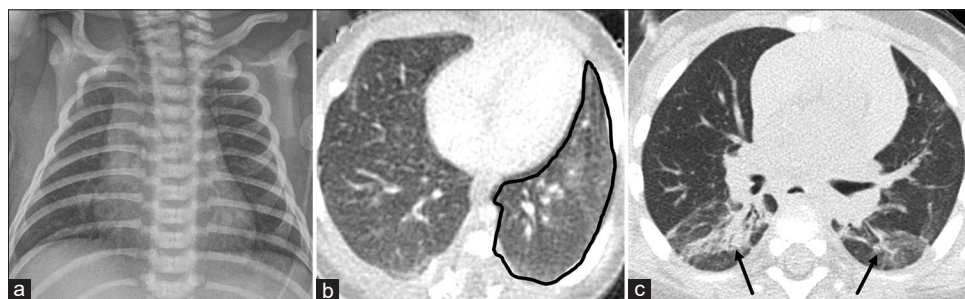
(a) Chest radiograph on day of life #2 in a term infant experiencing desaturations shows nonspecific diffuse ground glass opacities. (b) Axial chest computed tomography image on day of life #9 demonstrates diffuse ground glass opacification (black outline). (c) Axial chest computed tomography image on day of life #270 shows bibasilar atelectasis and scarring (black arrows). This patient was found to have colony-stimulating factor 2 receptor B mutation
